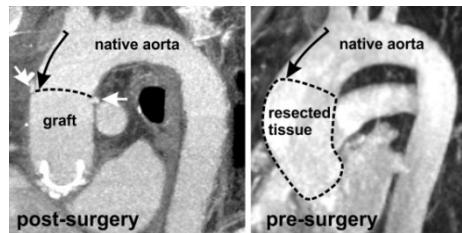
The region of resected tissue was determined by pre- & post-surgical CE-MRA / CTA. The anastomosis (left, white arrows) and surgical notes indicated the type of procedure and the location of removed tissue. The distance of the anastomosis from the brachiocephalic (left, black arrow) was used to determine the resection region (right).
